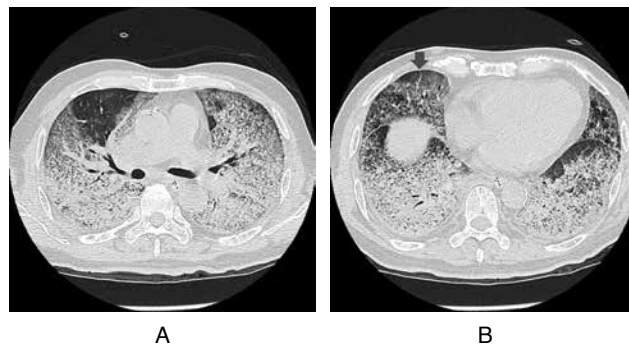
Chest CT during acute phase of illness
